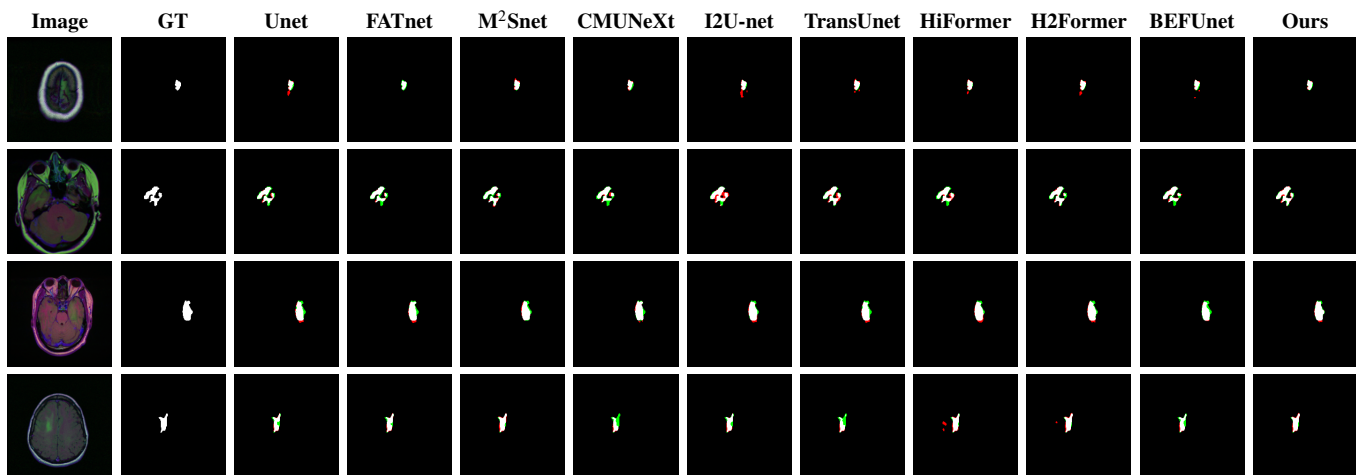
Visualisation of Brain Tumor MRI datasets. Red represents over-segmentation, green under-segmentation, and white correct segmentation.
